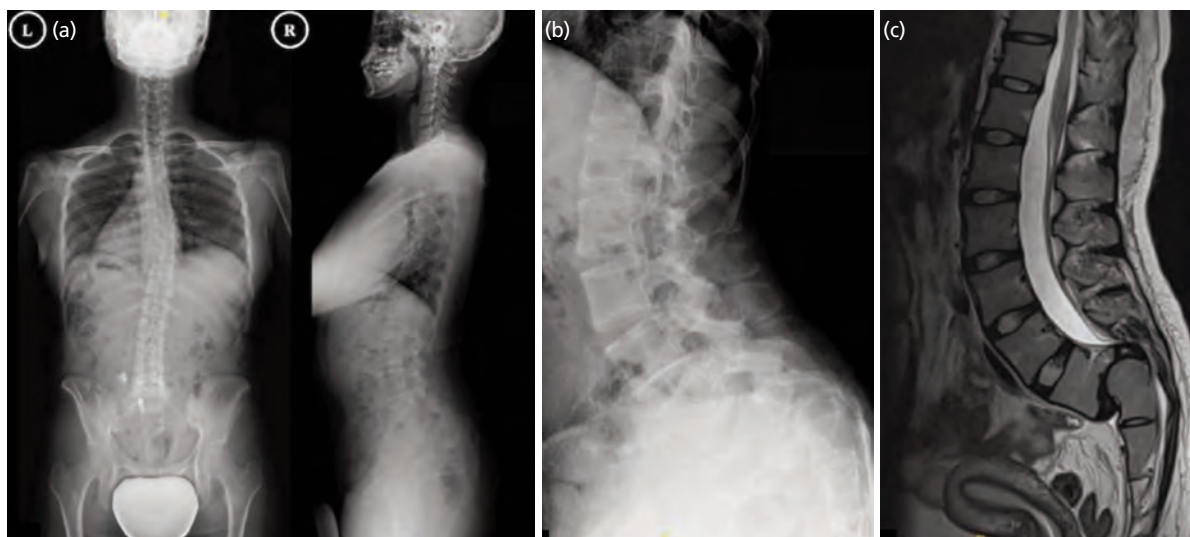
Pre-operative radiographic and MRI images. (a, b) Pre-operative radiographs demonstrated high-grade spondylolisthesis of L5/S1 (Meyerding classification grade IV). (c) Sagittal view of T2-weighted MRI demonstrating a severe compression of dural matter and nerve roots at L5/S1 level, with dysplastic features of dome-shaped sacral promontory and anterior slippage of L5 vertebra on S1 upper endplate.
